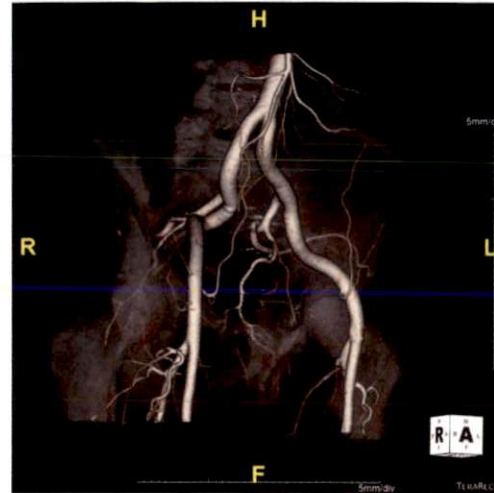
CT angiogram - used for planning
